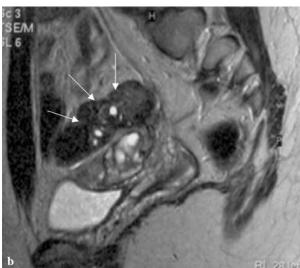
2a) Bowel barium enema : profile view 2b) MRI of sigmoid endometriosis
